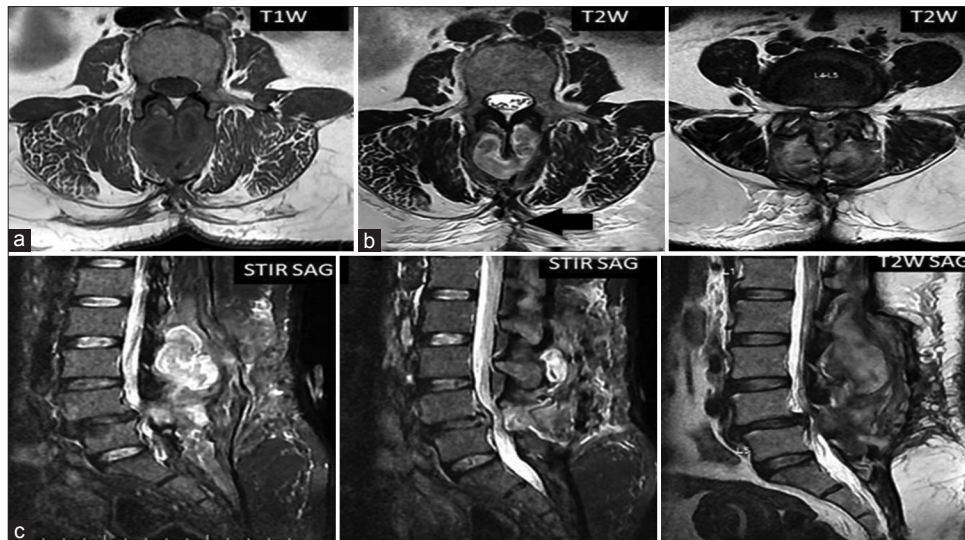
The axial magnetic resonance imaging (MRI) images shows T1W isointense (a) and T2W hypointense (b) signal of retained gauze piece inside posterior paraspinal abscess of lumbar spine. The sagittal T2W/short tau inversion recovery (c) MRI images shows hyperintense signal of paraspinal abscess (from L2 to L5 level) surrounding the gauze piece and the ill-defined posterior lumbar sinus tract (black arrow)
